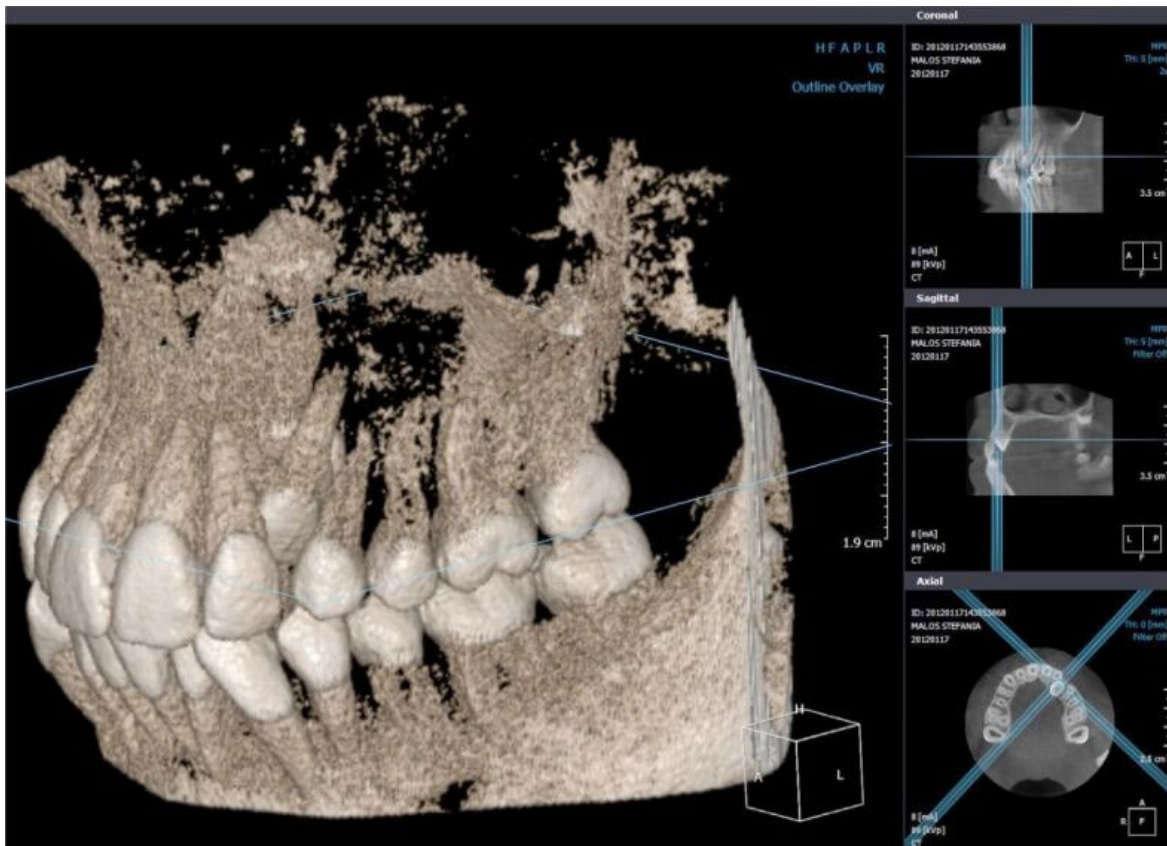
3D CT scan: coronal, sagittal and axial section. (Personal case). *(Rom J Morphol Embryol,2022)*
